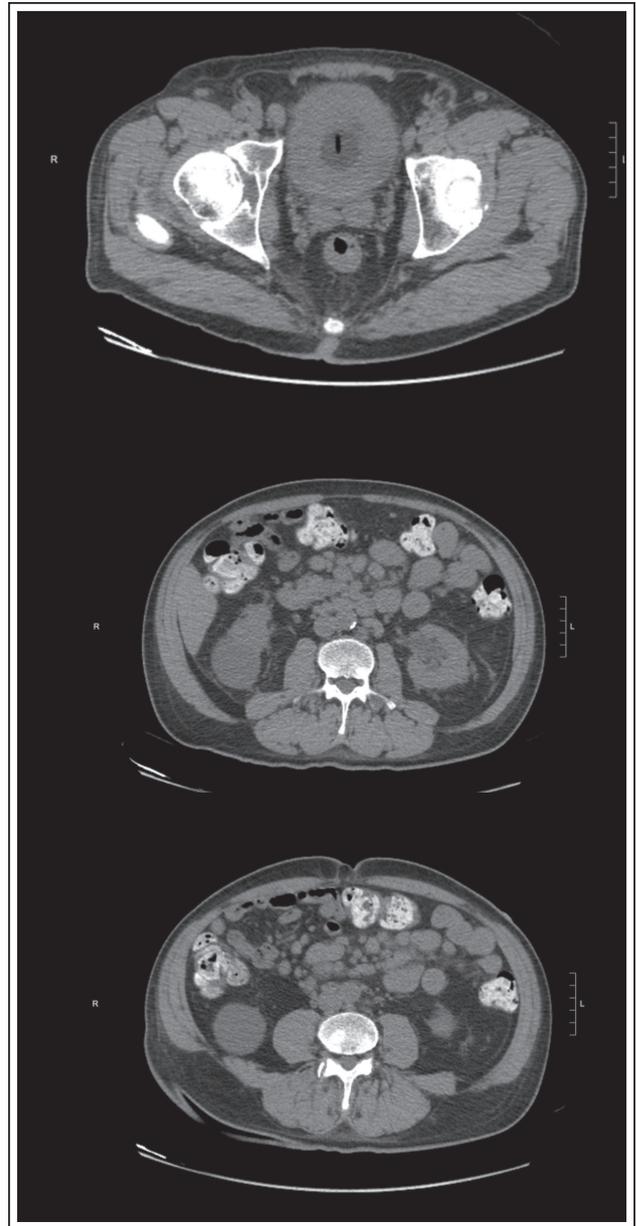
CT of abdomen and chest – second admission – (A) Thickened bladder wall; (B) Mild left hydronephrosis with diffuse retroperitoneal lymphadenopathy; (C) Mesenteric lymphadenopathy.
